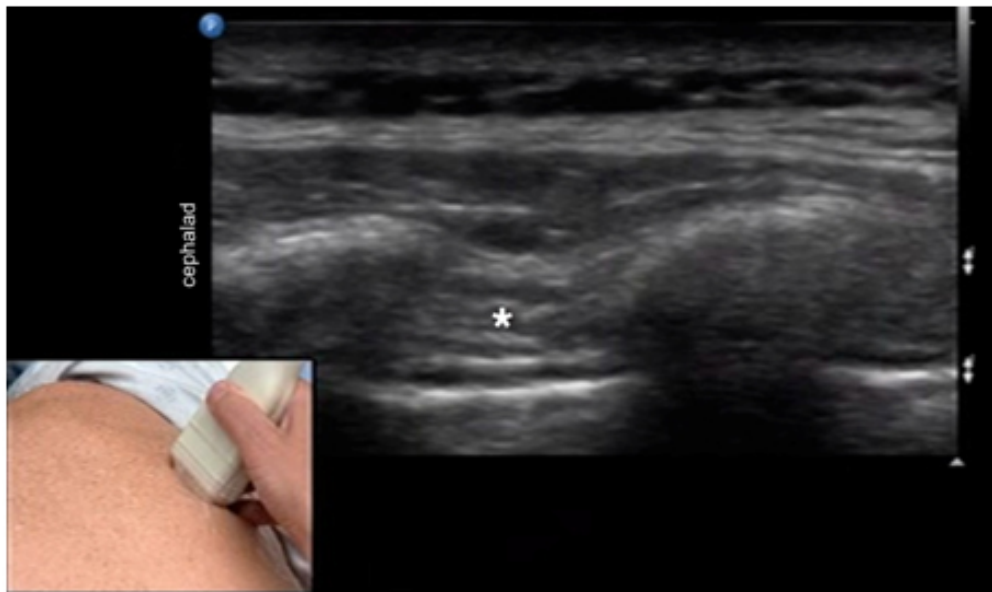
Sonogram showing the intercostal space lateral to the costal angle denotes fascial layer between the external and internal intercostal muscles; the intercostal nerve is not visualized in this region (Patel and Joshi, 2013).
